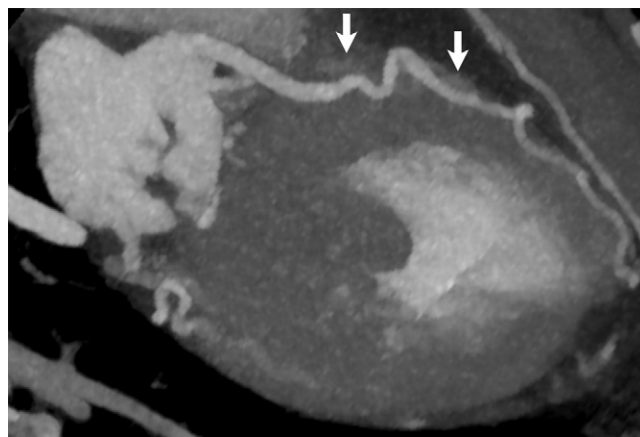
Maximum intensity projection reformatted coronary CT angiography image shows tortuous left anterior descending coronary artery with myocardial bridging (arrows) in a 68-year-old woman who was later found to have fibromuscular dysplasia.
